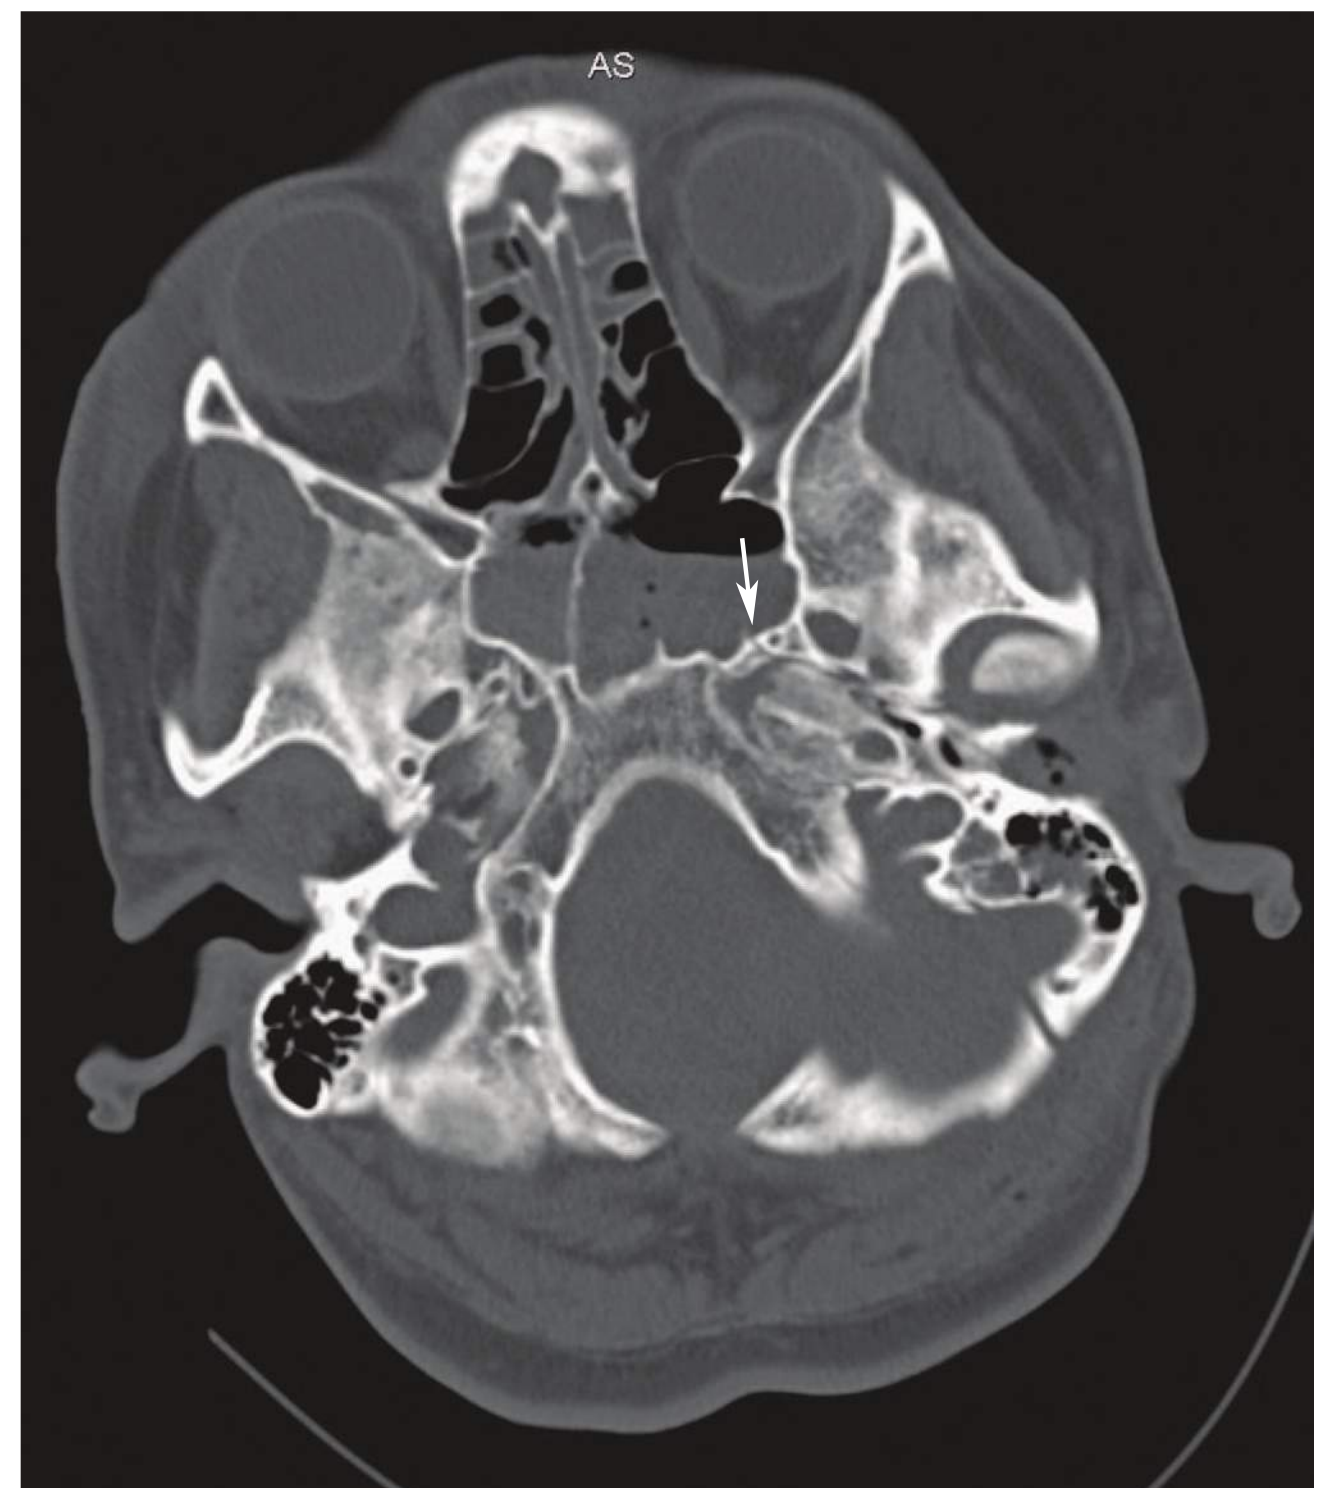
■ CT of Basilar Skull Fracture. CT bone window demonstrates a fracture of the posterior wall left sphenoid sinus (arrow) and an air-fluid level. (Photo contributor: Jared McKinney, MD.)
